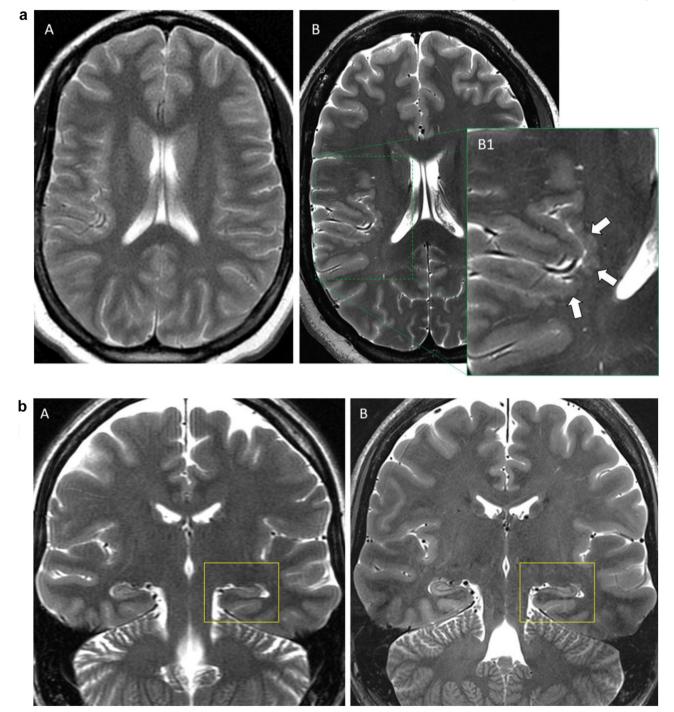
Sample imaging of lesions visible on 7T imaging. 1a. Patient 14, Polymicrogyria. Axial T2-weighted imaging at 1.5T (A) and 7T (B). The posterior insular polymicrogyria was not detected at 1.5 T but is clearly resolved at 7T (see lobulated gray matter pattern emphasized by arrows in magnified 7T inset, B1) 1b. Patient 8, Hippocampal Asymmetry. Coronal T2 weighted images at 3T (A) and 7T (B). The 7T image has superior visualization of both hippocampal formations, and in particular more precisely highlights the contours of the smaller left side hippocampus better than the 3T scan was able to.
